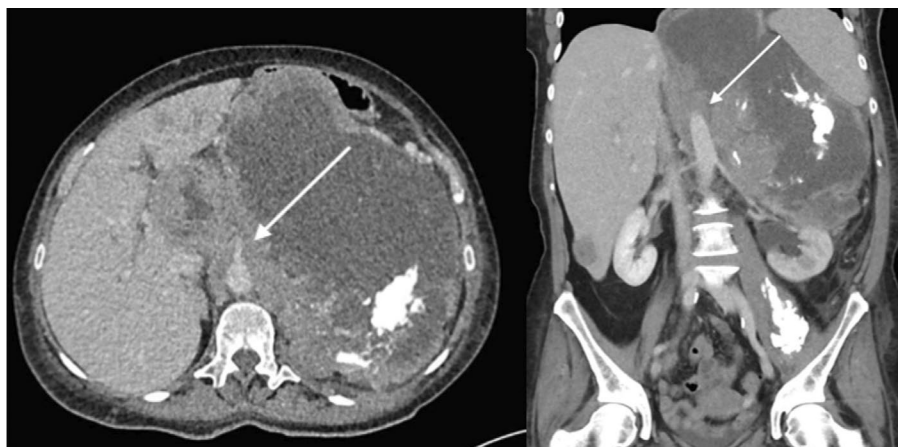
Computer tomography (CT) axial and coronal imaging demonstrating an unresectable RPS secondary to aortic involvement (arrow).
